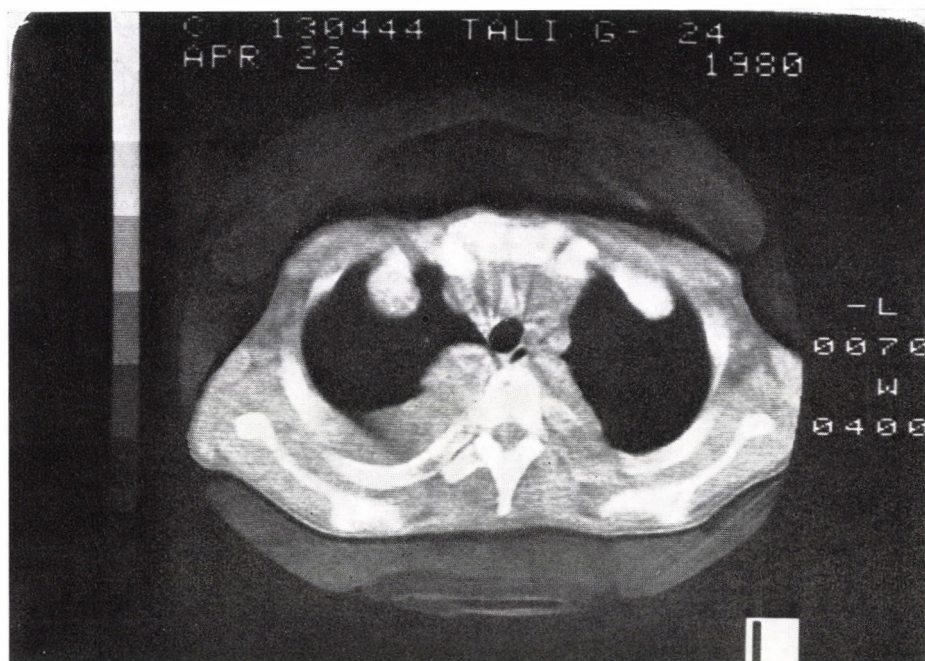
CAT: masses of extramedullary erythropoiesis in the paravertebral fossae and at parasternal and subcostal sites
